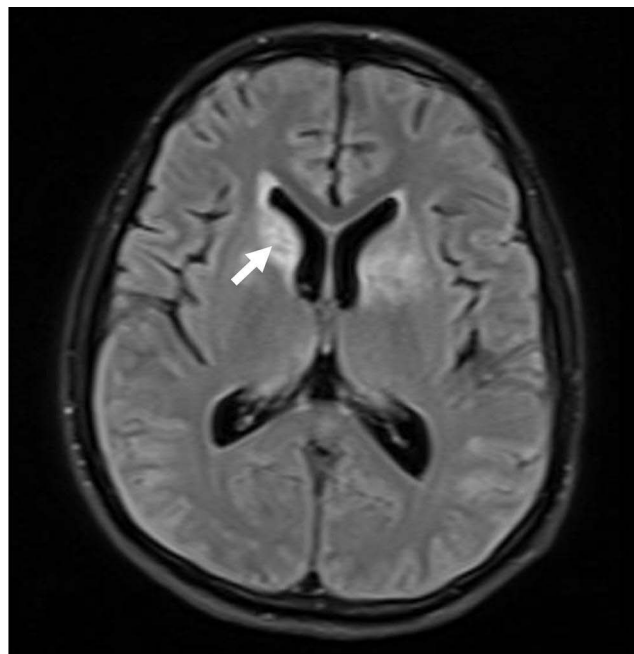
Brain MRI showing altered signal intensity in the head of the caudate nucleus (arrow), lesions in the splenium of the corpus callosum, ventricular nuclei, and the anterior arm of the left internal capsule.
